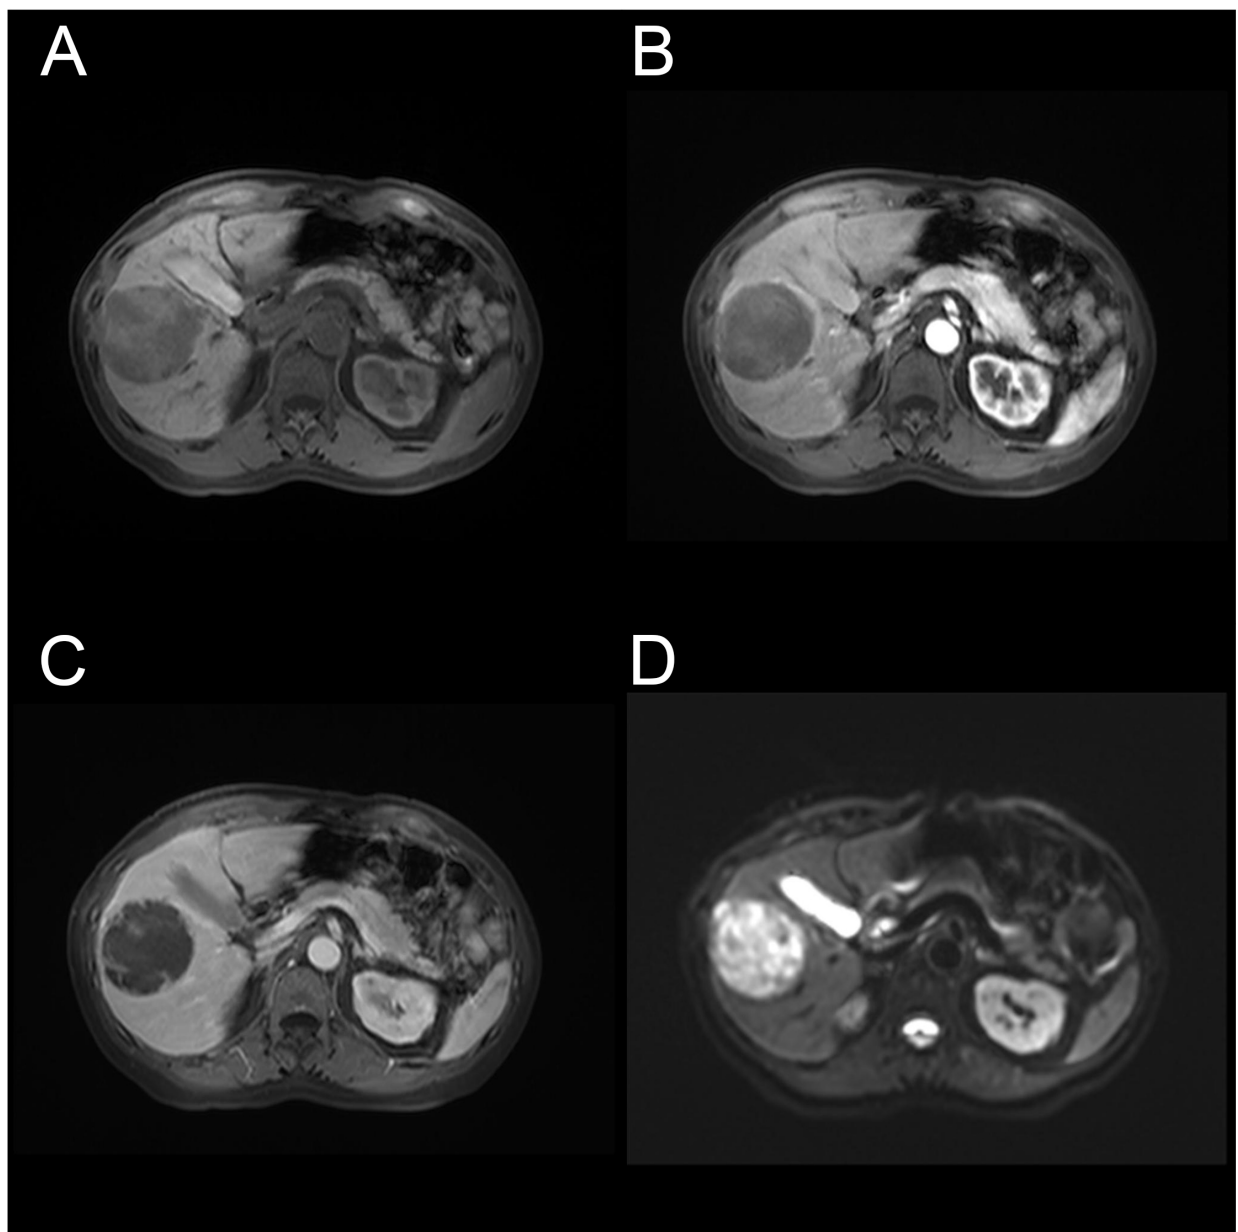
Preoperative MRI evaluation. (A) T1 weighted scanning. (B) Artery phase of enhanced MRI scanning. (C) Portal vein phase of enhanced MRI scanning. (D) DWI scanning.
